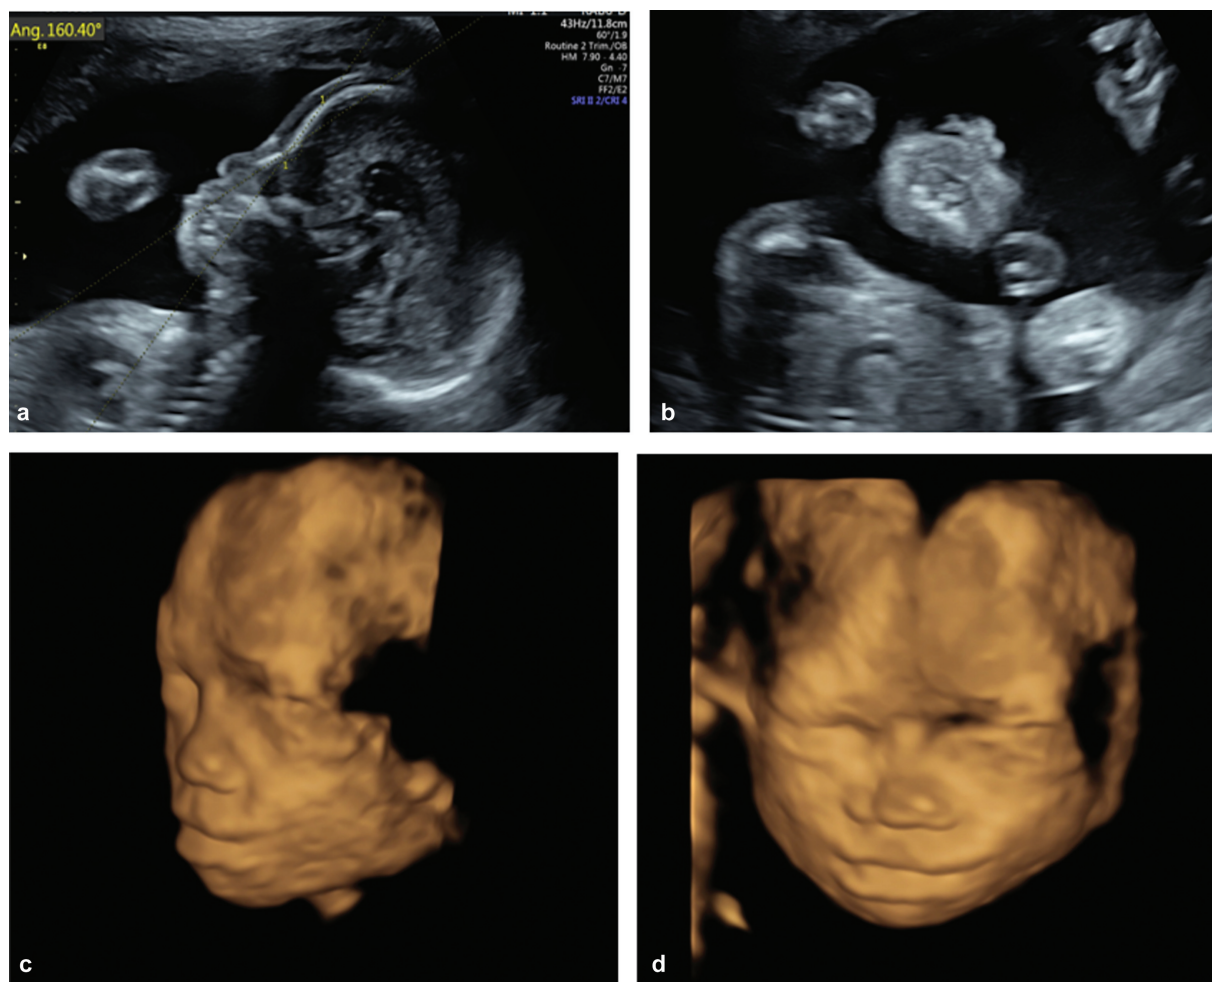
Case 7—Antenatal ultrasound (US) images. Two-dimensional US showing antenatal images of flattened midfacial profile (a), short columella, flat nasal tip, and alar wings (b) and three-dimensional US showing flat facies (c, d).
